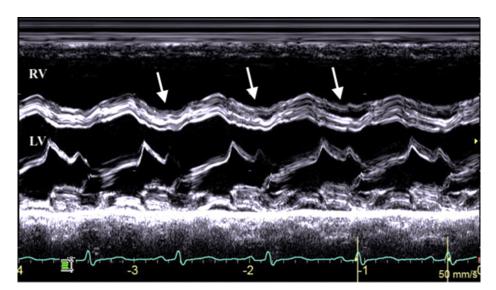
M-mode echocardiography oriented in a parasternal short-axis view showing diastolic septal flattening (*white arrows*) from volume overload of the RV.
